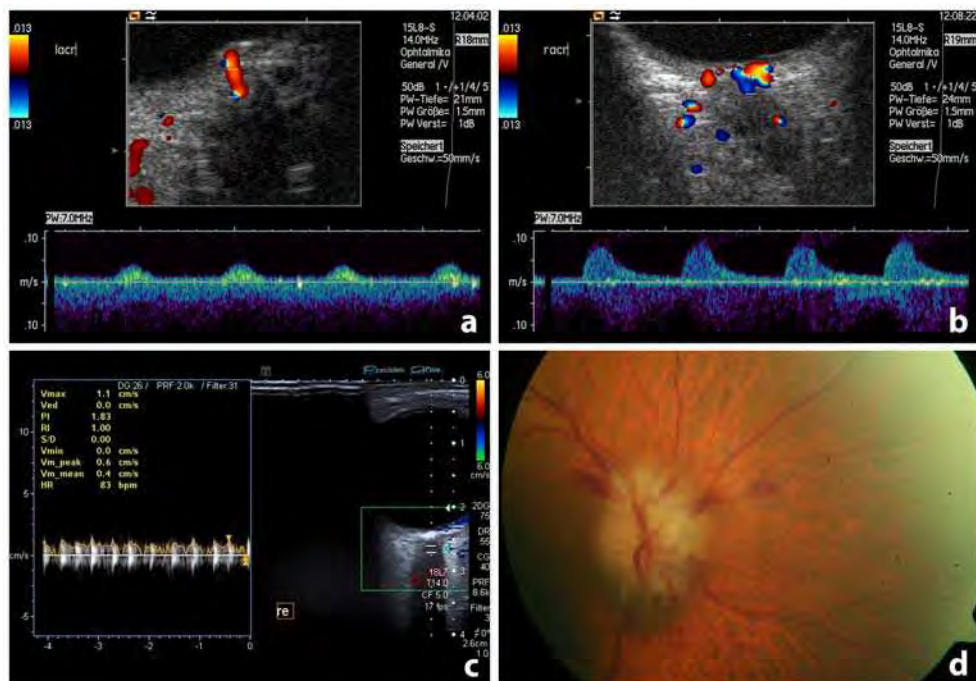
Ultrasound and funduscopic findings in patients with central retinal artery occlusion due to temporal arteritis. (a) Patient 1: Color-Duplex- and spectral Doppler-mode: Pseudovenous flow in the affected CRA. (b) Patient 1: Color-Duplex- and spectral Doppler-mode: normal flow in the unaffected contralateral CRA. (c) Patient 2: Color-Duplex- and spectral Doppler-mode: zero-flow in the affected CRA. (d) Patient 2: funduscopy: blurred rim of optic disc, optic disc edema and hyperemia, small splinter hemorrhage
